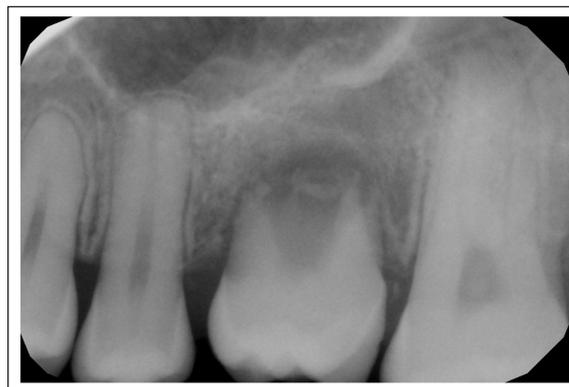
The intraoral x-ray of autotransplanted wisdom tooth, 3 months later
